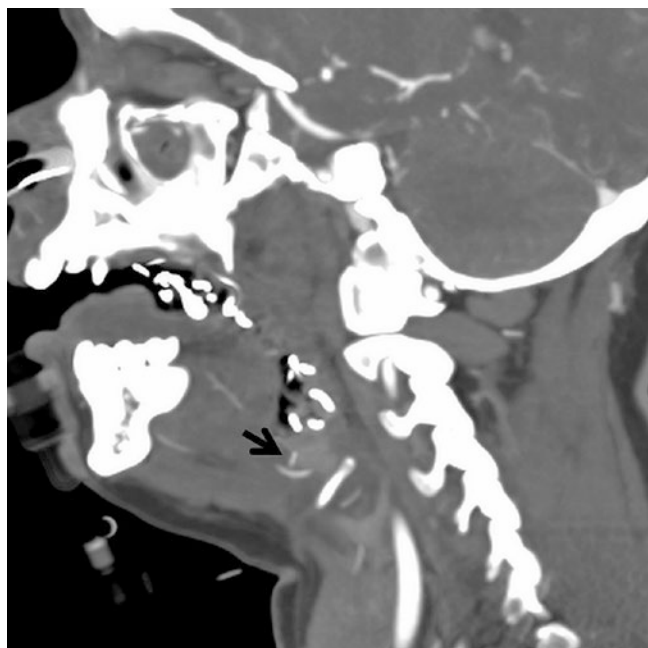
Injury to the lingual artery. Patient with oropharyngeal bleeding after tonsillectomy. CTA demonstrates a focus of active extravasation (arrow) adjacent to the lingual artery. Note the hemorrhage and packing material within the oropharynx
